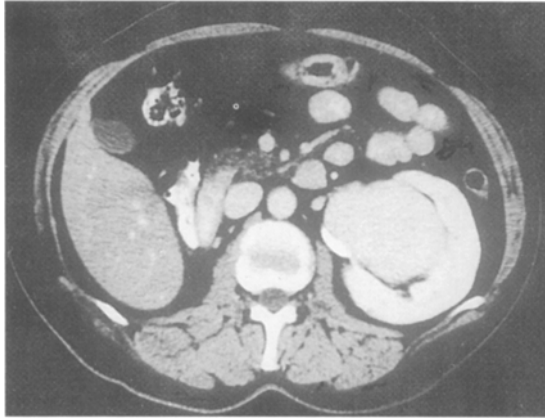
CT shows a mass of 7 cm extending from the renal pelvis and involving the parenchyma with post-contrast enhancement
